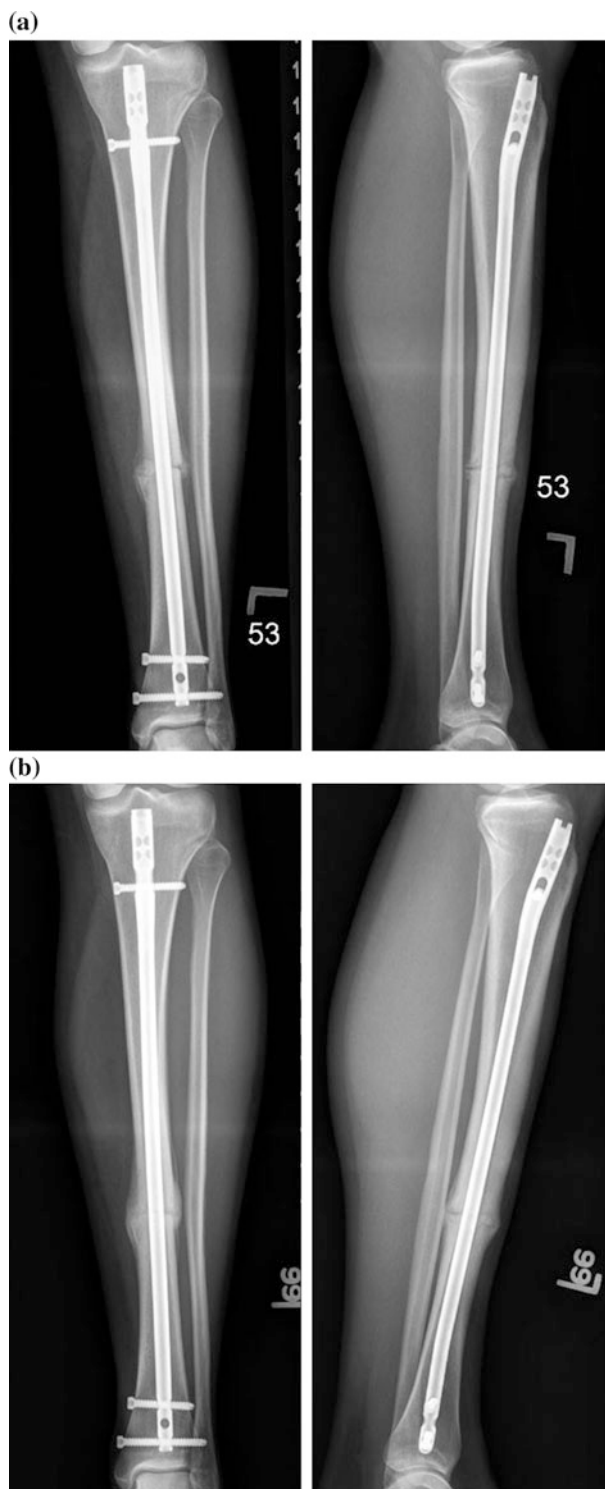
Radiographic union score for tibia (RUST) fracture healing assessment. Assignment of RUST in a patient with distal tibial shaft fracture at 3 months. a At 4 weeks, there is healing callus along the medial, lateral, and anterior cortices, but fracture lines are visible. RUST score = 8. b At 10 weeks, there is bridging callus and no fracture line at the anterior and medial cortices. Fracture lines are still visible posteriorly and laterally. RUST score = 10
